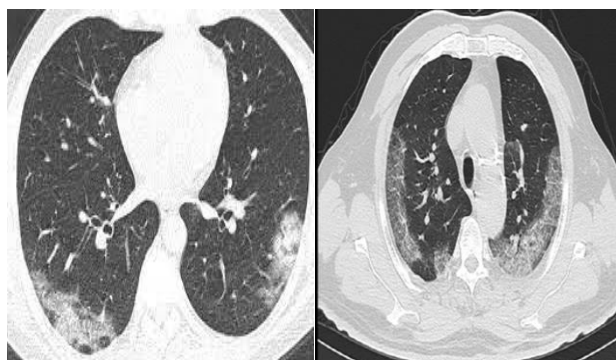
HRCT chest showing bilateral patchy confluent ground glass opacities with peripheral predominance.
